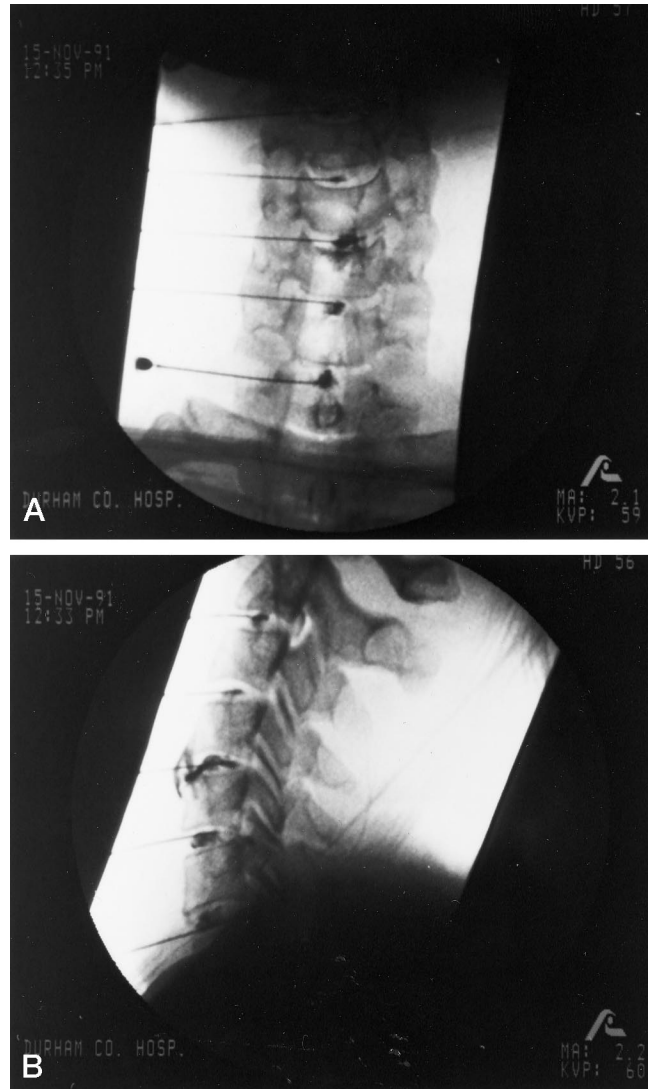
Anteroposterior (A) and lateral (B) radiographs taken during cervical discography of a 32-year-old man. Radiographs show needle placement at C2–C3 through C6–C7. All levels are normal in appearance and nonpainful except for C4–C5, which produced concordant (like home) pain and appears degenerative.
